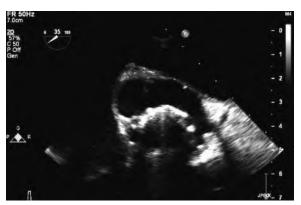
Transesophageal echocardiography image showing pseudoaneurysm. (Courtesy Dr. Nandan Anavekar, Mayo Clinic.)
